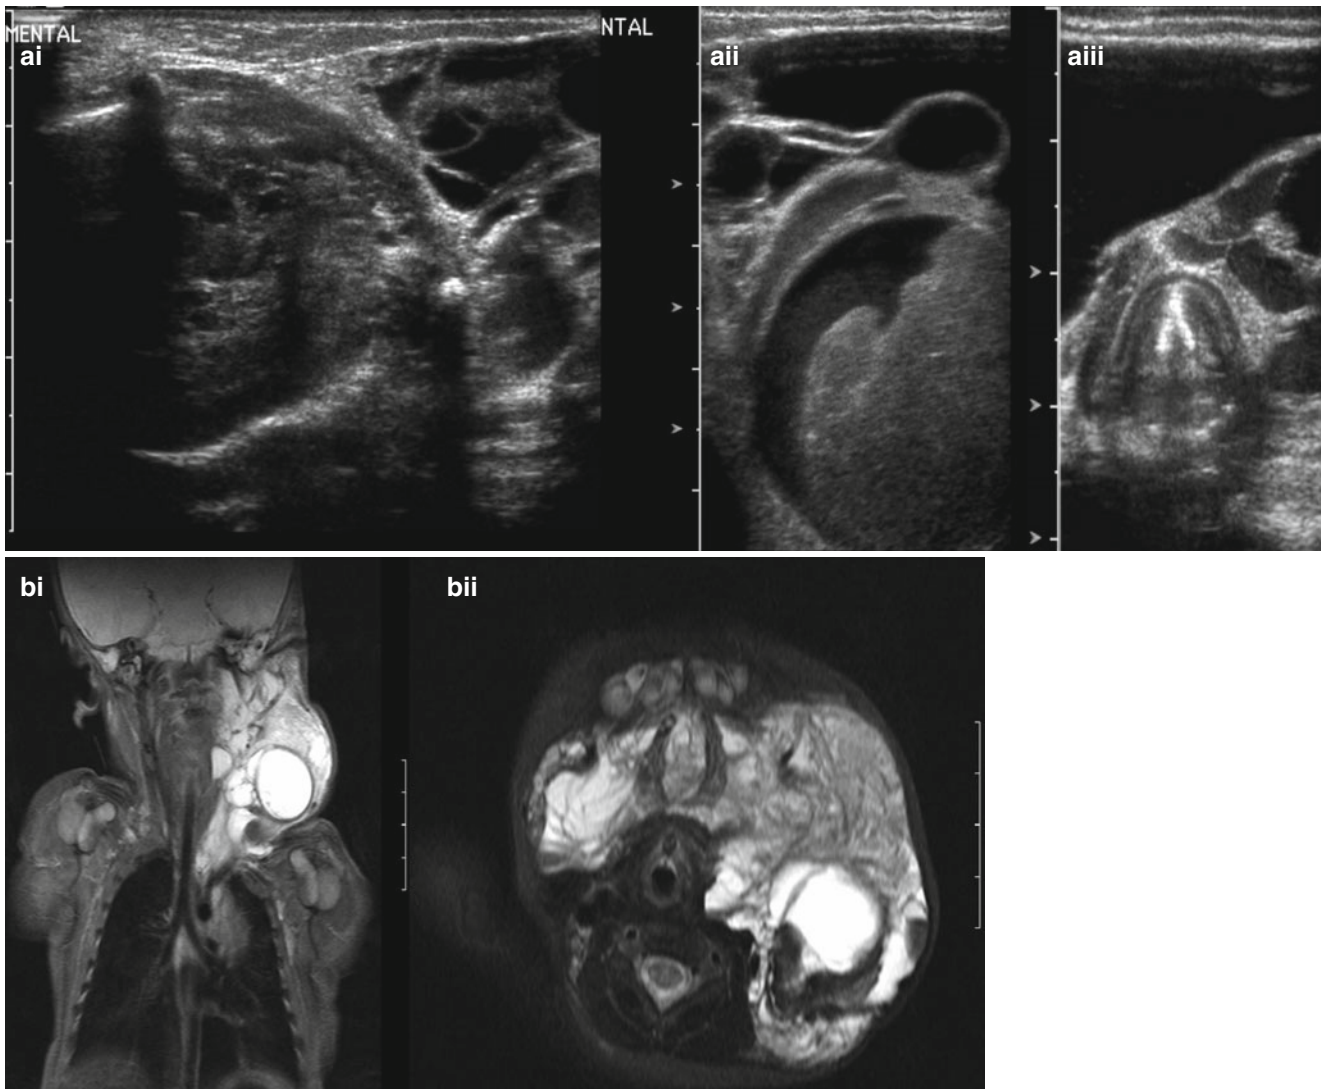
Cystic hygroma in the neck. (a) Ultrasound showing a bulky tumor of heterogenous echo texture with (i) solid components and (ii) cystic structures and (iii) extending across the midline (the vocal cords
